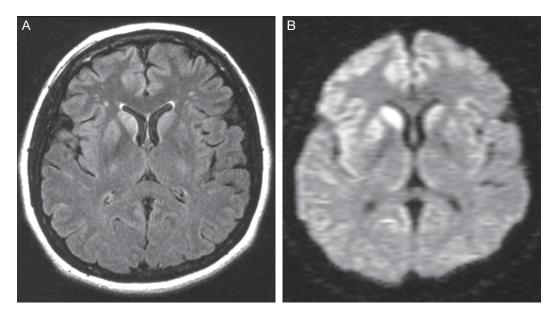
Abbreviations: DWI, diffusion-weighted imaging; EEG, electroencephalography; MRI, magnetic resonance imaging.
